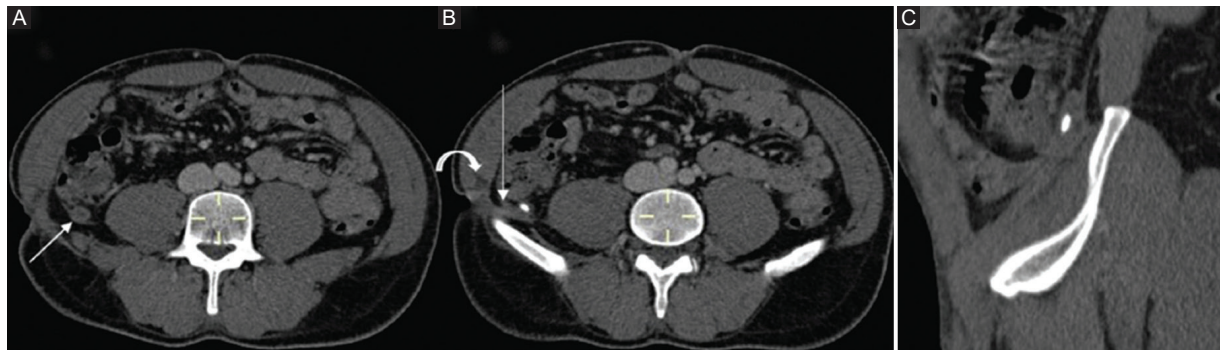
Computed tomography images with intravenous contrast at venous phase. A: axial image showing the distended appendix distal segment, with thickened wall with increased uptake. B: axial image in a section just proximal to the anterior one showing the hyperdense appendicolith and allowing to identify the fistulous path (straight arrow), which extends from the appendix to the cutaneous surface; a small abscessed collection can also be observed on adjacent musculature (curved arrow). C: sagittal image showing appendix ascending retrocecal location, with appendicolith and distal appendicular segment distension.
